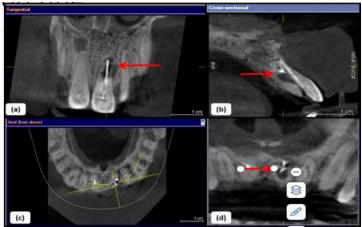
CBCT images (a) Tangential view, (b) Cross-sectional view, (c, d) Axial view depicting communicating internal and external resorption Arrows show communicating internal resorption.
